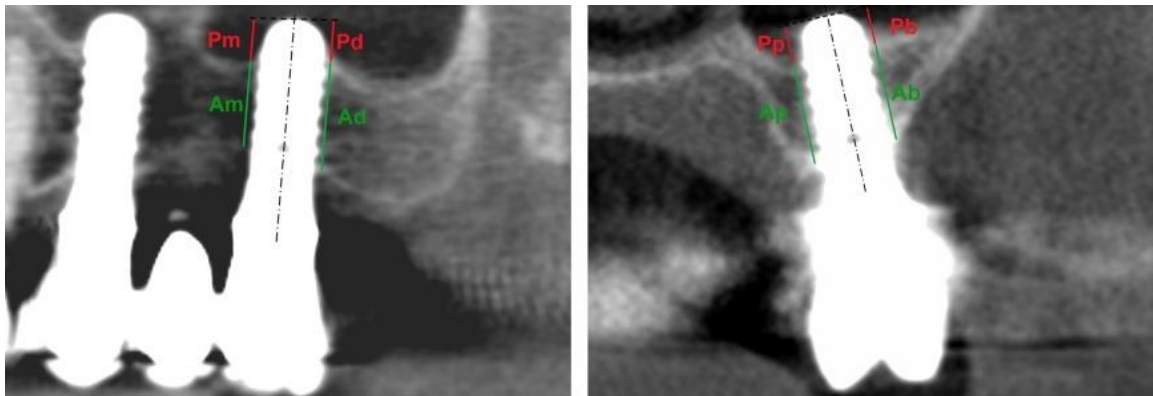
Parameters measured on CBCT images:
